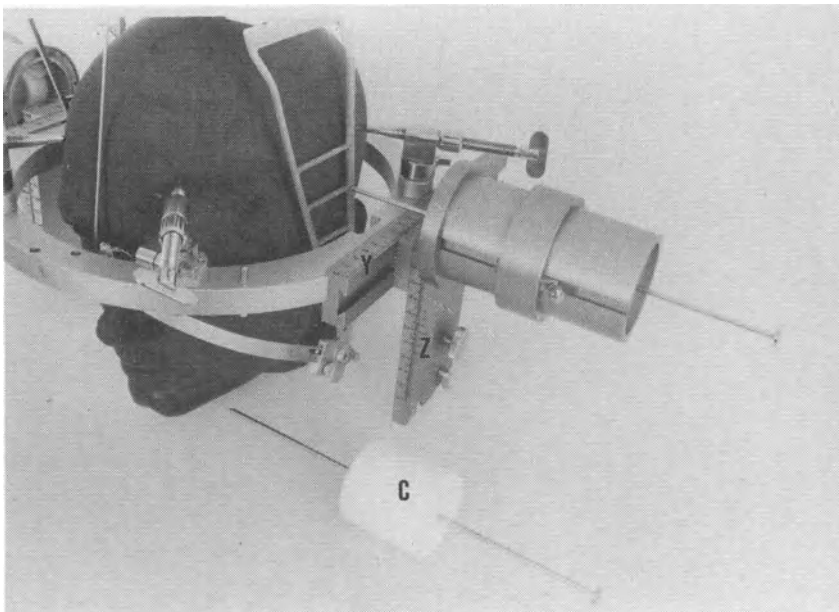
Stereotactic surgery without radiography in the operating room. The base ring is mounted parallel to the transverse arms of the adapter. By means of a cylinder block (C) with an axial steel pin, the cylinder component is positioned on the base ring so that its axis coincides with the Y-Z origin of the adapter. The position is read on the Y and Z scales of the frame.
